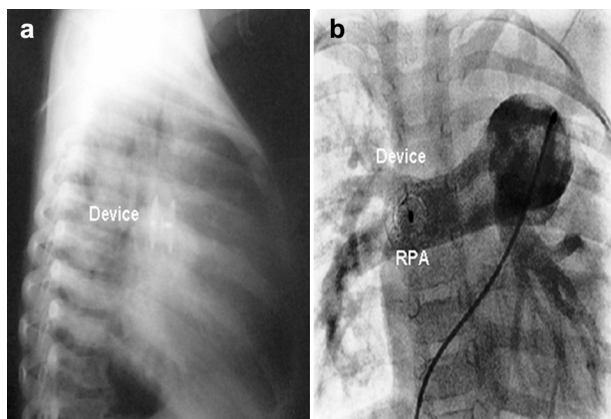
(a) Lateral chest X-ray showing the amplatzer device in the pulmonary artery position. (b) AP view at cardiac angiography showing the amplatzer device at the right pulmonary hilum.
